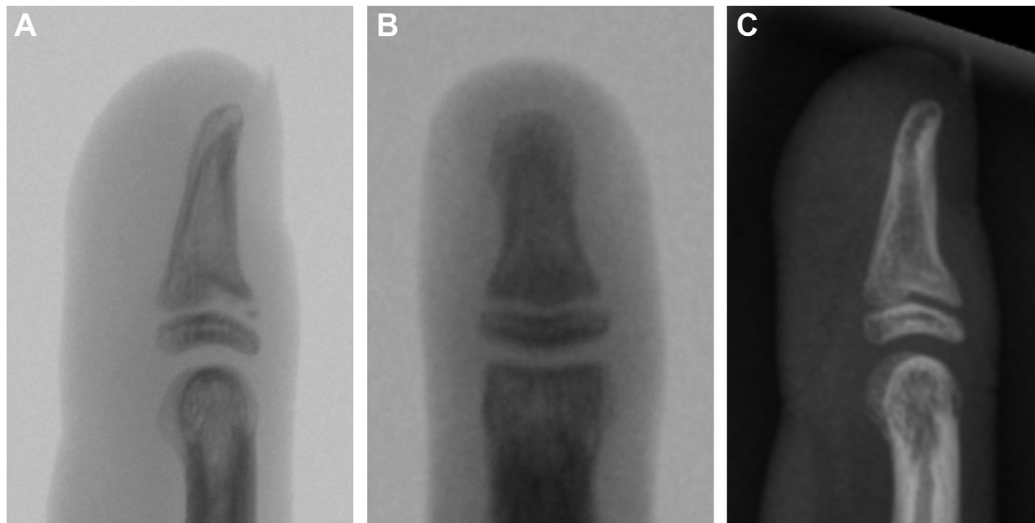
A and B, Radiographs of the distal phalanx of the right middle finger. C, Radiographic consolidation of the right middle finger after 3 mo.
